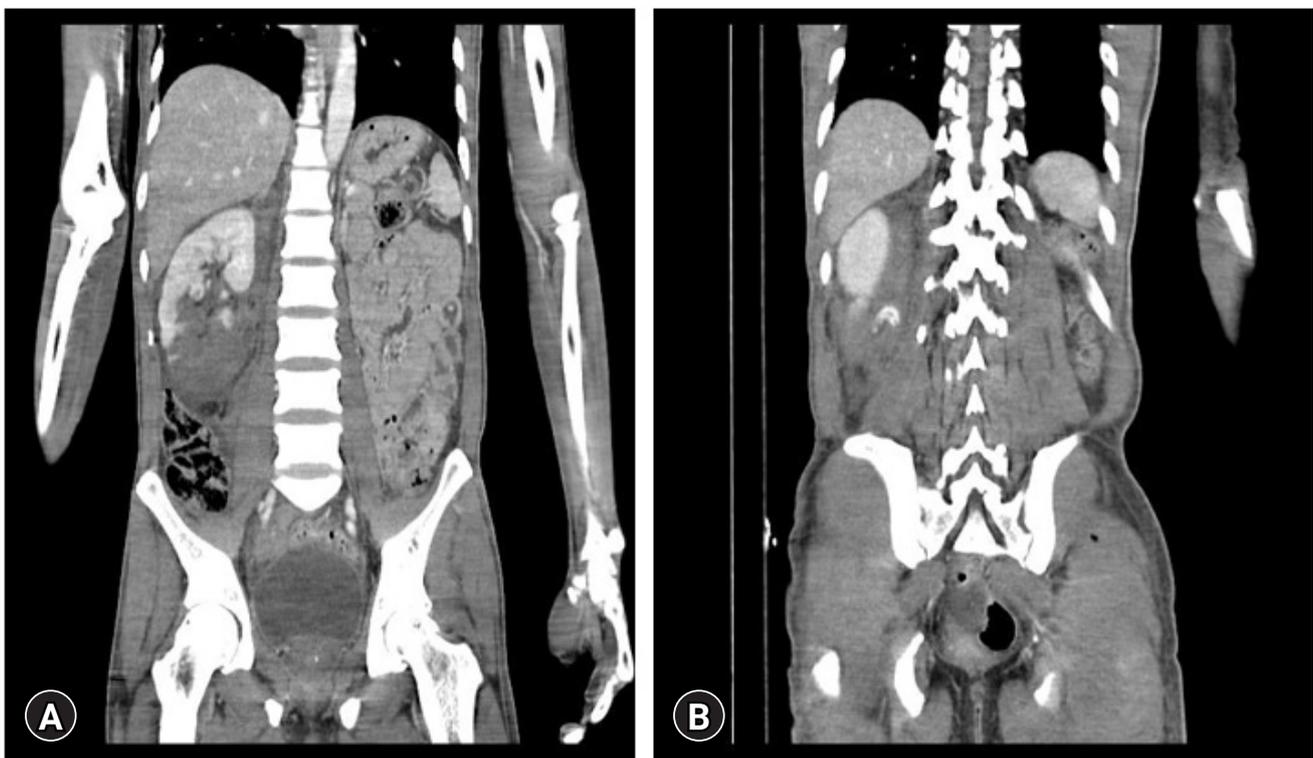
Coronal view of contrast-enhanced computed tomography shows (A) a shattered low pole of the right kidney and (B) extravasation of contrast. A perirenal hematoma was also present.
